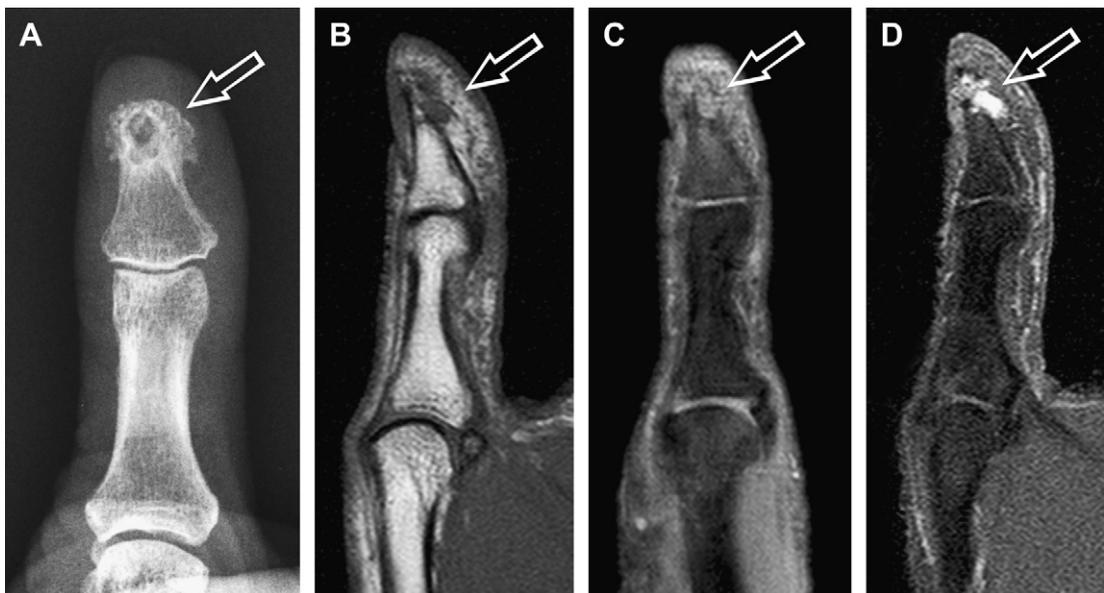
Glomus tumor. Glomus tumor (arrow) in a 57-year-old woman with left thumb pain. (A) Anteroposterior radiograph of the thumb demonstrates prominent bone erosion of the terminal tuft. (B) Sagittal T1W (TR/echo time [TR/TE], 760/16.7) MR image demonstrates an intermediate-signal 6-mm mass on the volar aspect of the terminal tuft. The lesion is intermediate signal on (C) coronal proton density-weighted (TR/TE, 1500/10) fat-saturated image and demonstrates avid contrast enhancement on (D) sagittal T1W (TR/TE, 570/16.7) image with fat saturation.
